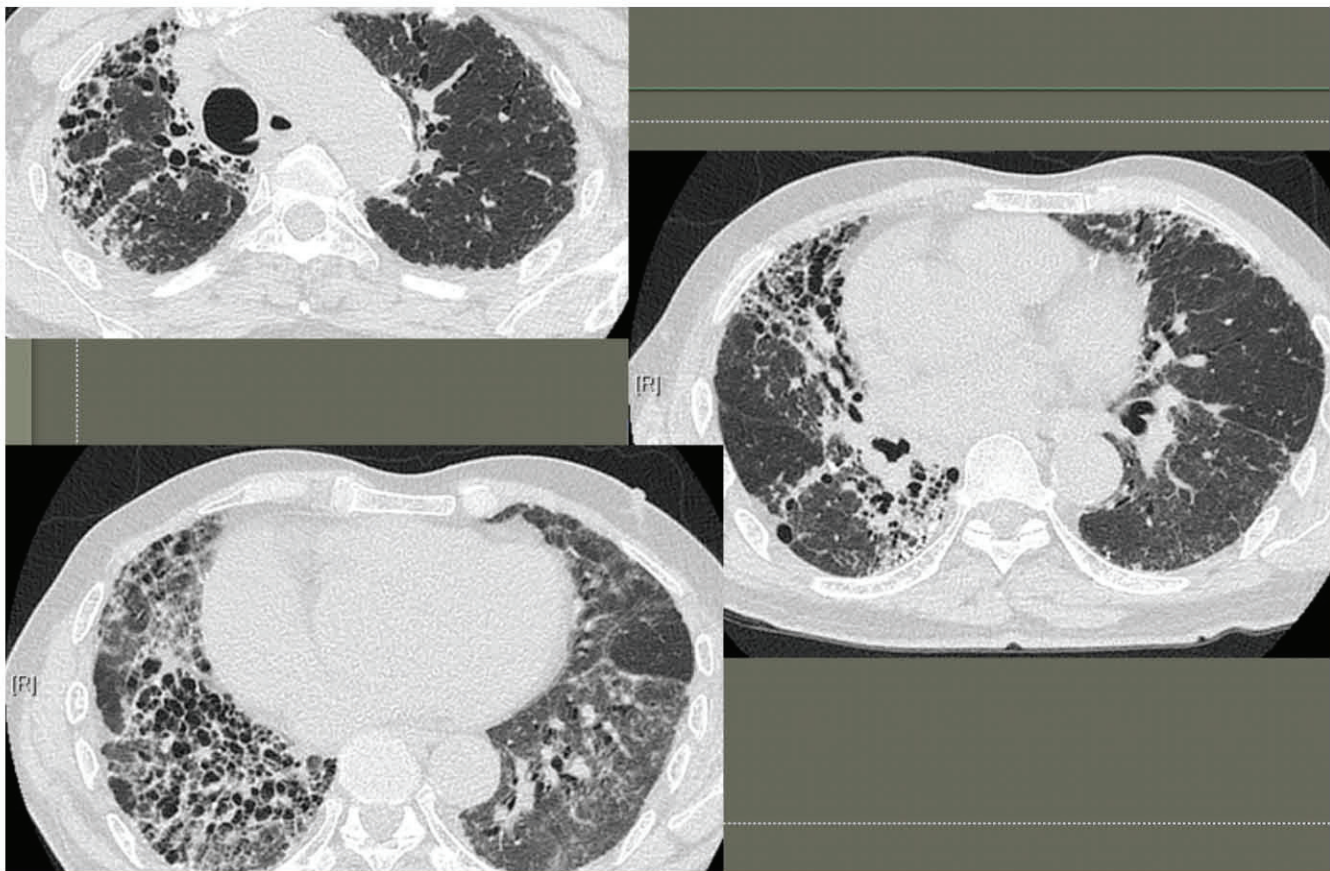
HRCT at 4 years after second bilateral WLL
